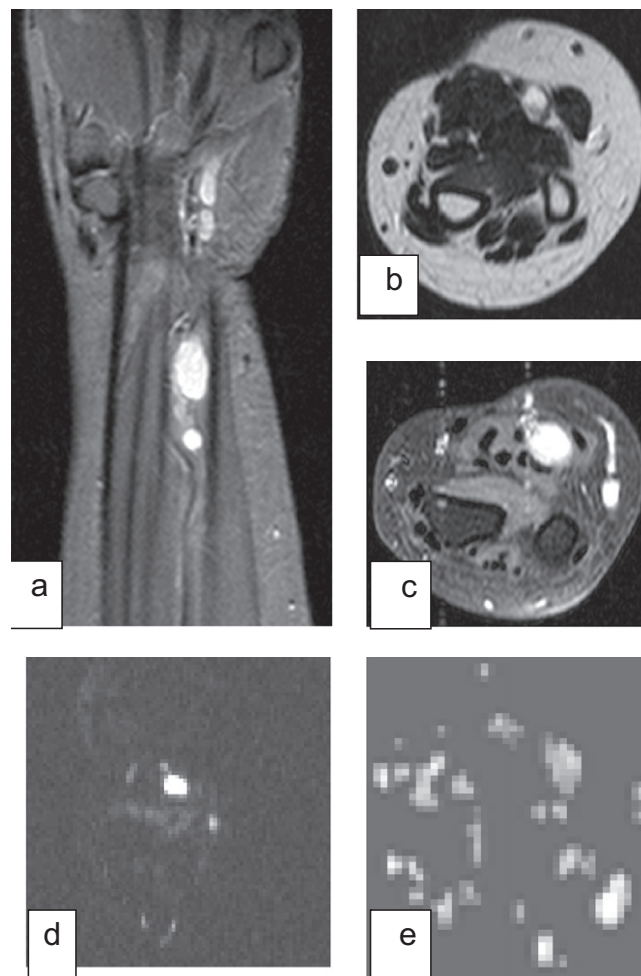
Cystic Neurofibroma appears of low signal in coronal T1WIs(a), high signal in axial T2WIs and fat suppression sequence (b,c). No restriction in DWI(d,e) and ADC. ADC Value 2.5 ± 0.04 .
